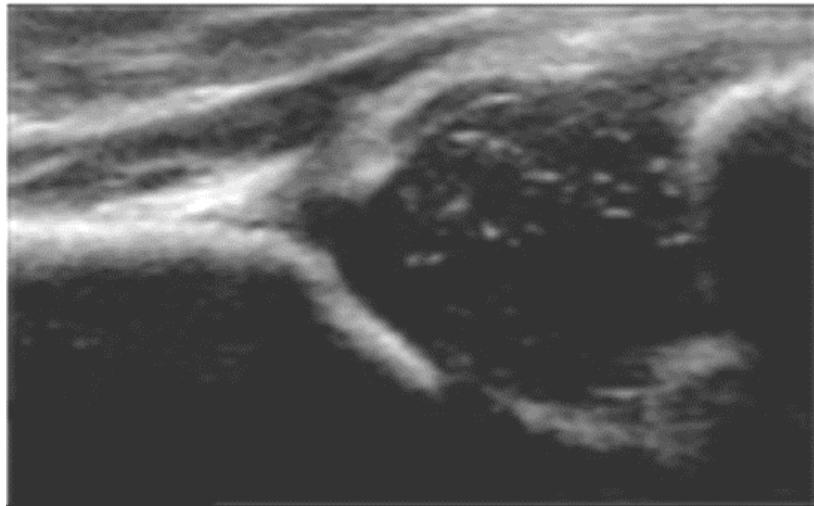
Ultrasound image of the hip joint.
